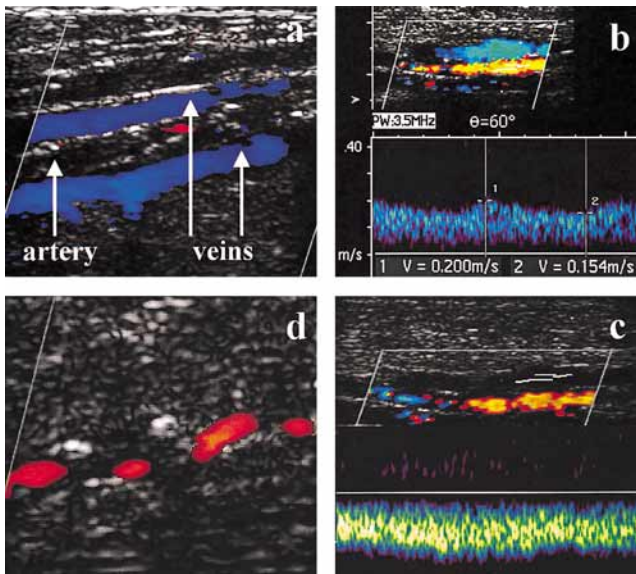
(a) The posterior tibial artery is clearly visualised with B-mode images, and there is no colour flow visualisation in the artery, indicating occlusion. Note the colour flow imaging of the vein; (b) the posterior tibial artery and the vein are visualised simultaneously, at the distal calf, in a patient with femoro-popliteal occlusion. The spectral Doppler analysis in the artery resembles venous flow, with low peak systolic velocity and continuous forward flow in the diastole due to critical limb ischaemia; (c) the venous flow in the adjacent vein. This patient underwent bypass to the posterior tibial artery; (d) heavily calcified anterior tibial artery with interrupted colour flow.
